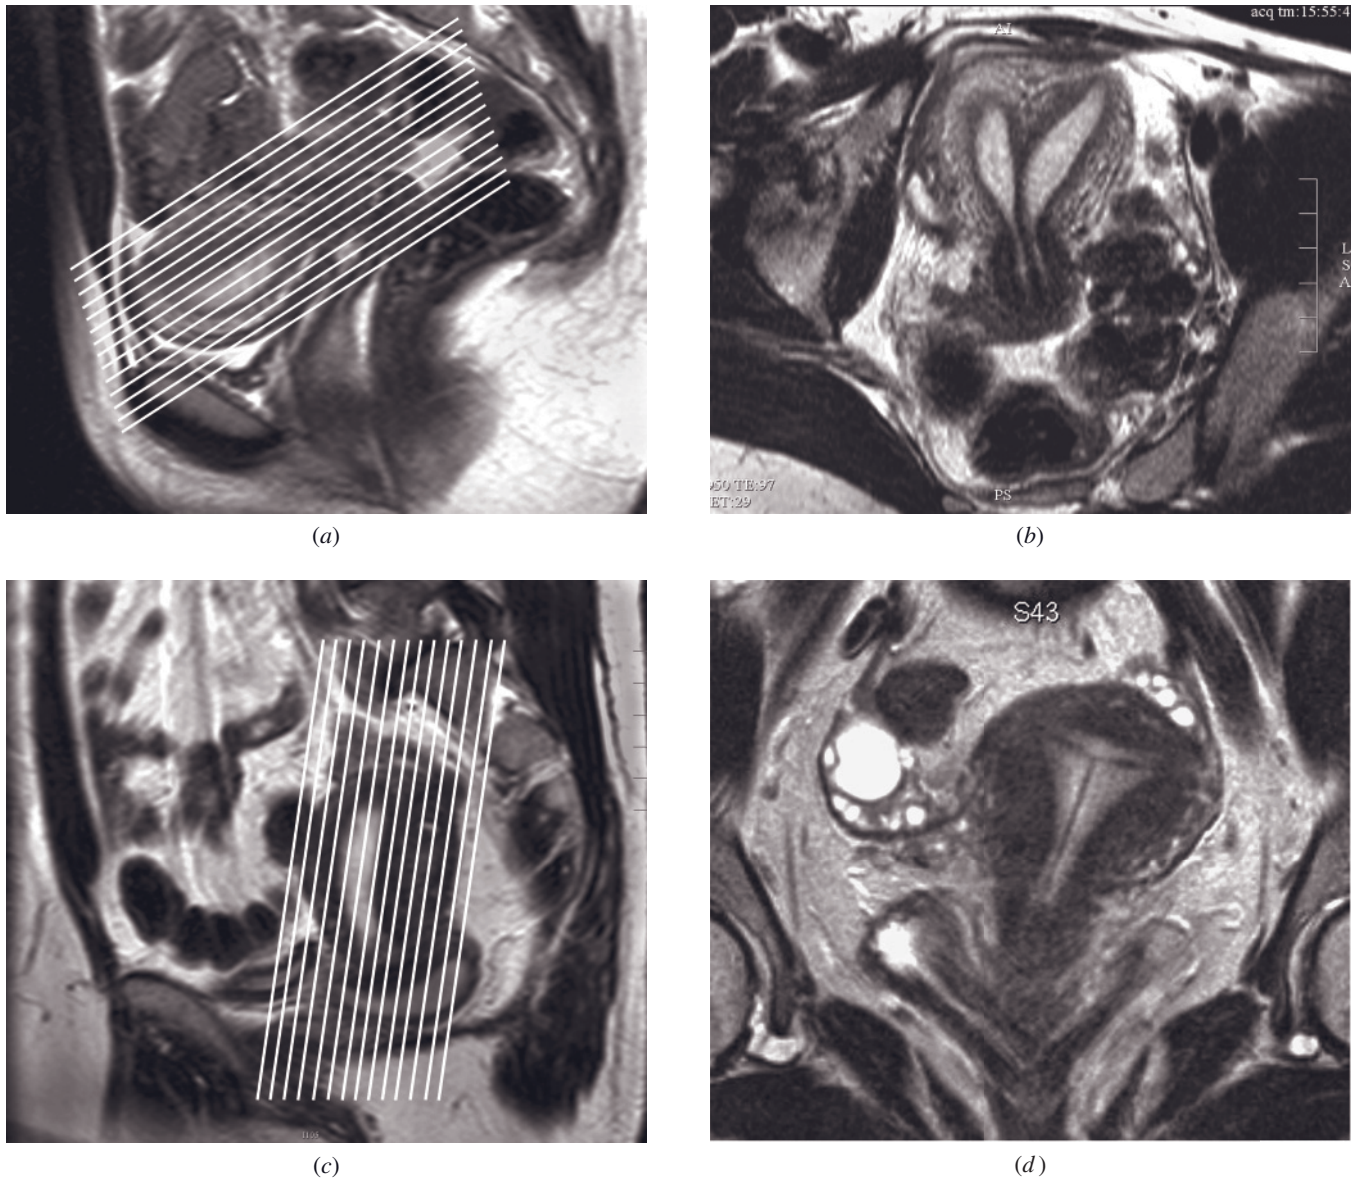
Long-axis view of the uterus in two patients. Sagittal (a) and oblique (b) T2-weighted ETSE images of a septate uterus. On the sagittal section (a), an imaging plane parallel to the endometrium is prescribed. The resultant long-axis view of the uterus (b) shows a muscular and fibrous septum with a normal convex fundal contour, which helps differentiate septate from bicornuate uteri. Sagittal (c) and oblique (d) T2-weighted ETSE images of a normal uterus. A sagittal image (c) is used to prescribe an oblique plane parallel to the endometrial canal. The long-axis view of the uterus (d) shows a correctly positioned IUD, seen as a hypointense T-shape within the endometrial cavity.
